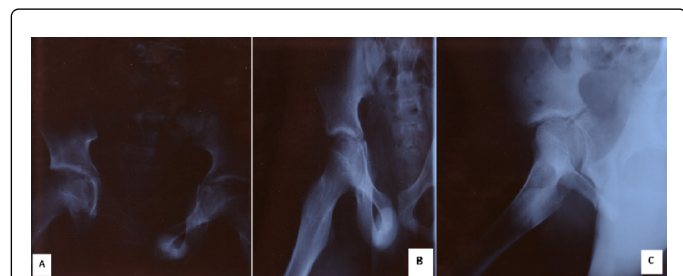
(A) X-ray pelvis of the face (B) Left frontal hip (C) Left ducroquet profile
